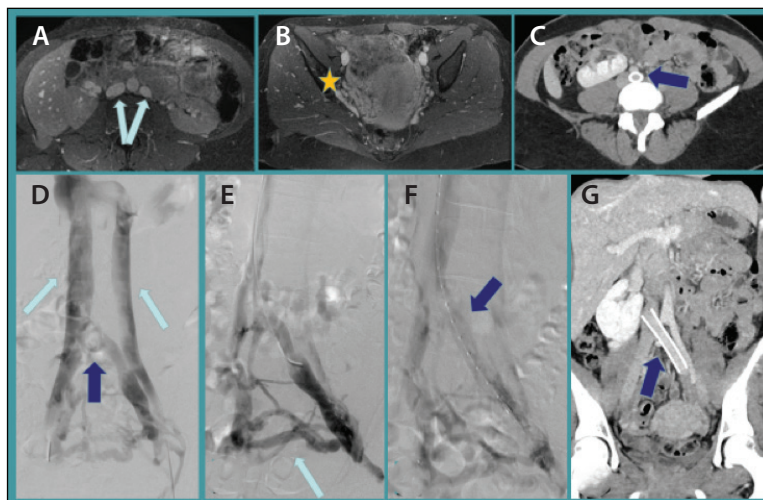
MR venography demonstrates a duplicated IVC (blue arrows, A) and significant pelvic varices (star, B) with crosspelvic collaterals. Duplicated IVC venography (D) shows compression of the limb (dark-blue arrow) connecting the left IIV and right IVC (light-blue arrows), resulting in significant retrograde contrast flow into the pelvic varices (light-blue arrow, E). Successful stenting (dark-blue arrow, F). Complete resolution of pelvic pain and patent stent (dark-blue arrows, C and G), as seen on CT venography at 16-month follow-up in axial and coronal views, respectively.
